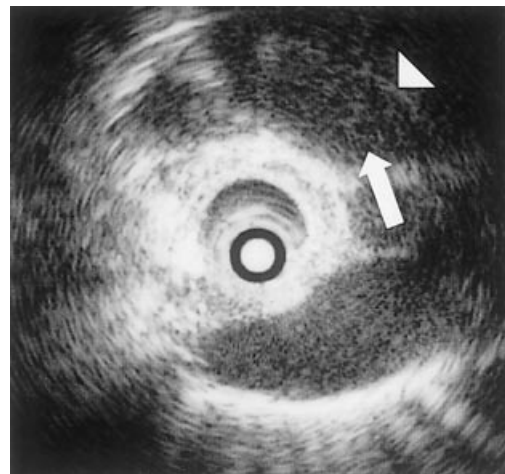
Endobronchial ultrasonography findings. The tumor (arrow) invasion was shown to be confined within the submuscle layer and not beyond the cartilage layer (arrow head).
